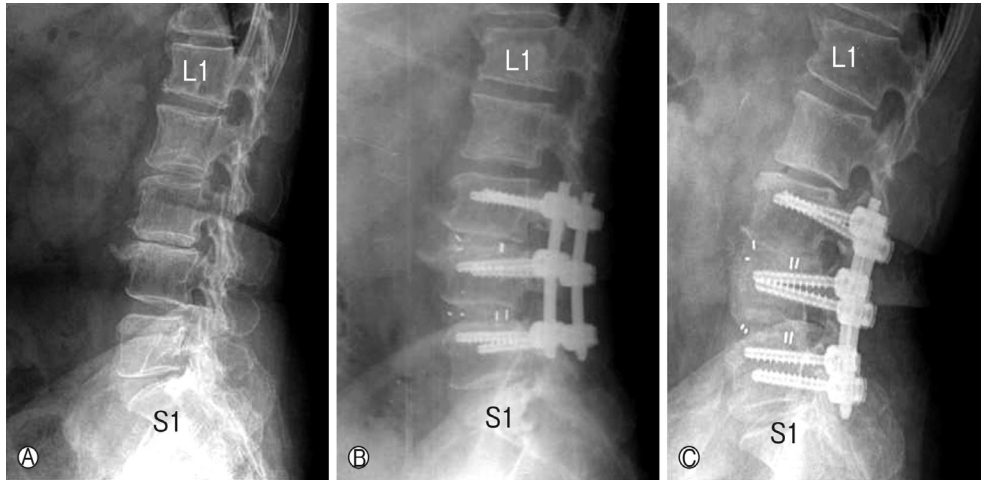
Series of lumbar spine of patient who showed development of adjacent segmental degeneration (ASD) at the last follow up period. A: Pre-operative plain lateral X-ray showed degenerative spondylolisthesis of L3 on L4 and disc space narrowing. B: 3 months after operation (posterior lumbar interbody fusion (PLIF) and posterolateral spinal fusion (PLSF) on L3-4-5 segments). C: At the last follow up period (1 year after operation), adjacent disc space of L2,3 narrowed significantly. And new spondylolisthesis of L2 on 3 was developed.
